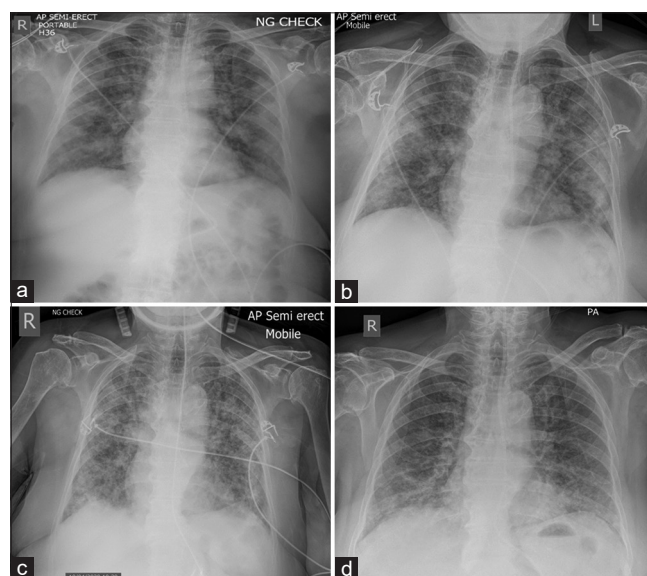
Serial chest X-rays showing the evolution characteristics changes in our patient. (a) Day 4: Showing the early bilateral infiltrates and positioning of the nasogastric tube. (b) Day 10: Worsening of the bilateral infiltrates (c) Day 15: Extensive bilateral infiltrates in keeping with a picture suggestive of ARDS. (d) Day 29: Chest X-ray prior to discharge demonstrating significant improvement in the previously seen infiltrates
